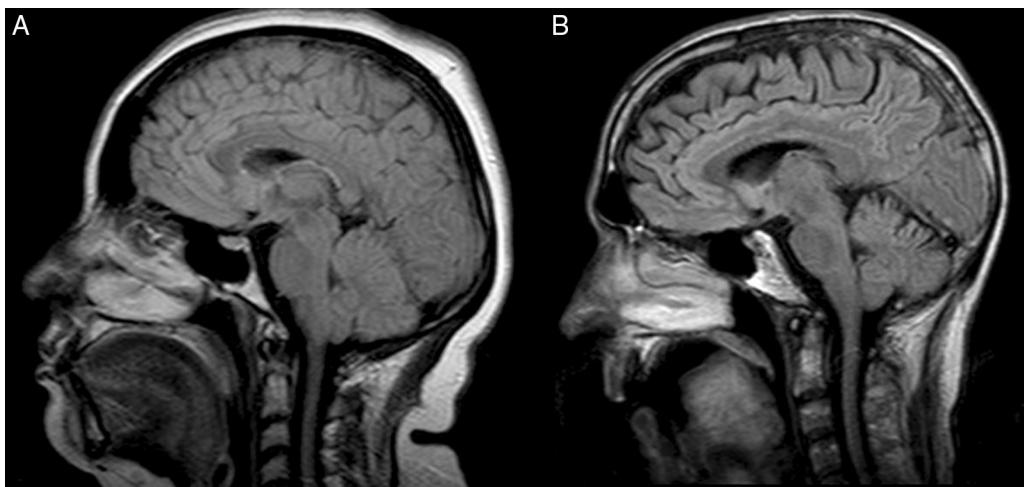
MRI scan. Sagittal, T1-weighted FLAIR sequence. (A) A 41-year-old woman with bulbospinal-onset ALS manifesting 6 months previously. The shape, position, and signal intensity of her tongue were normal, including the internal structures. (B) A 49-year-old man with bulbospinal-onset ALS manifesting 23 months previously. Abnormalities can be observed in the shape, position, and signal intensity of the tongue; the internal structure is lost.
